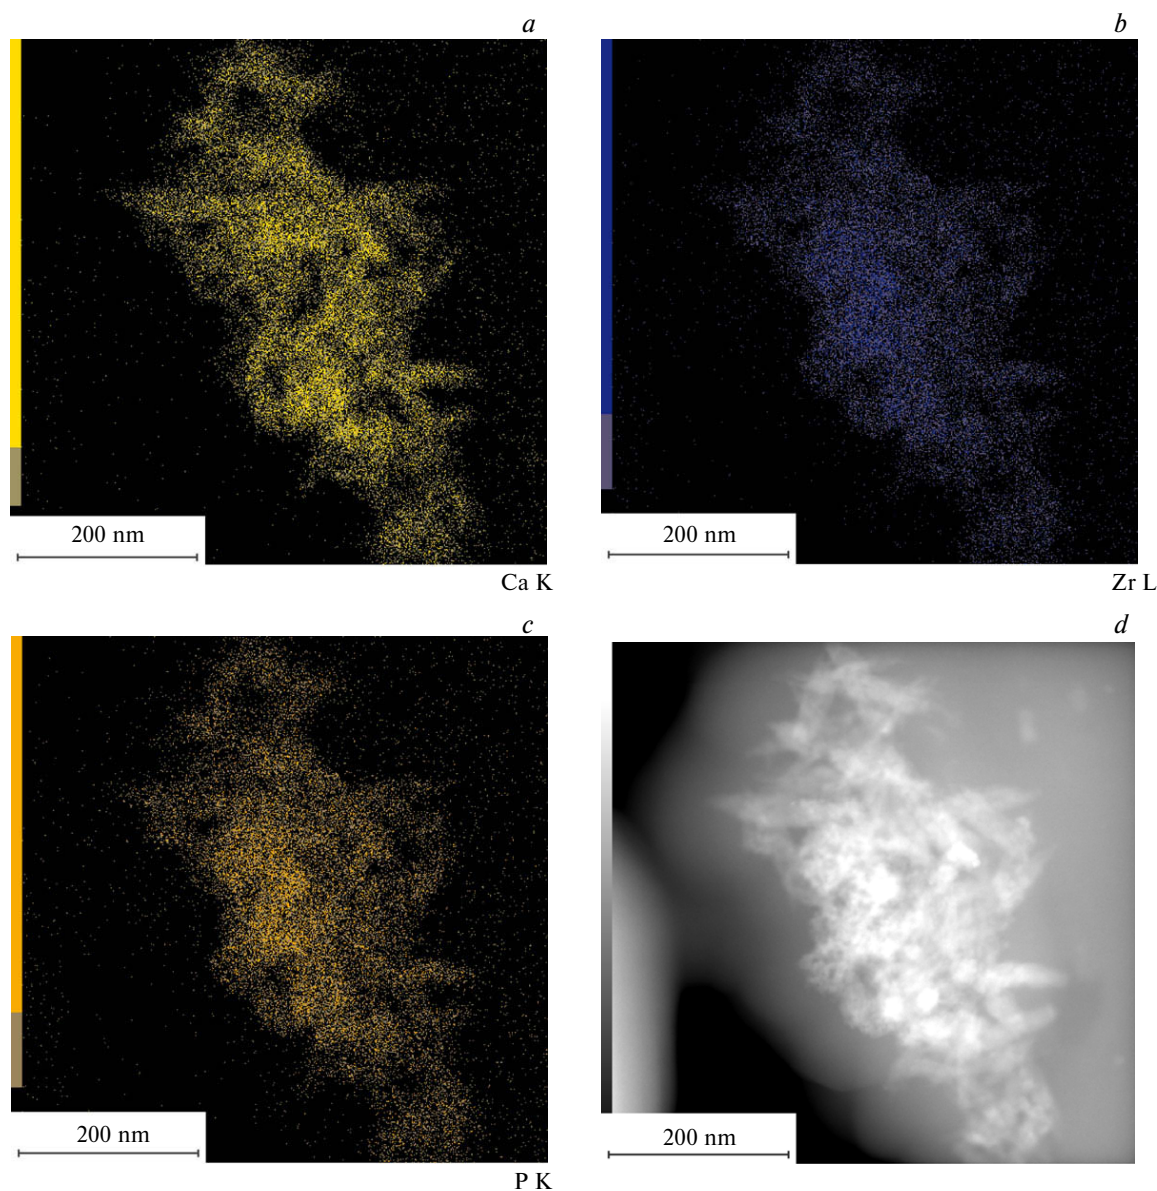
HR-TEM results for the HAP-Zr sample: mapping of the region of the sample surface with respect to various elements: calcium (a), zirconium (b), and phosphorus (c) and initial processed image of the sample obtained by the coprecipitation method (d); K and L are lines of characteristic X-ray radiation of the elements.
